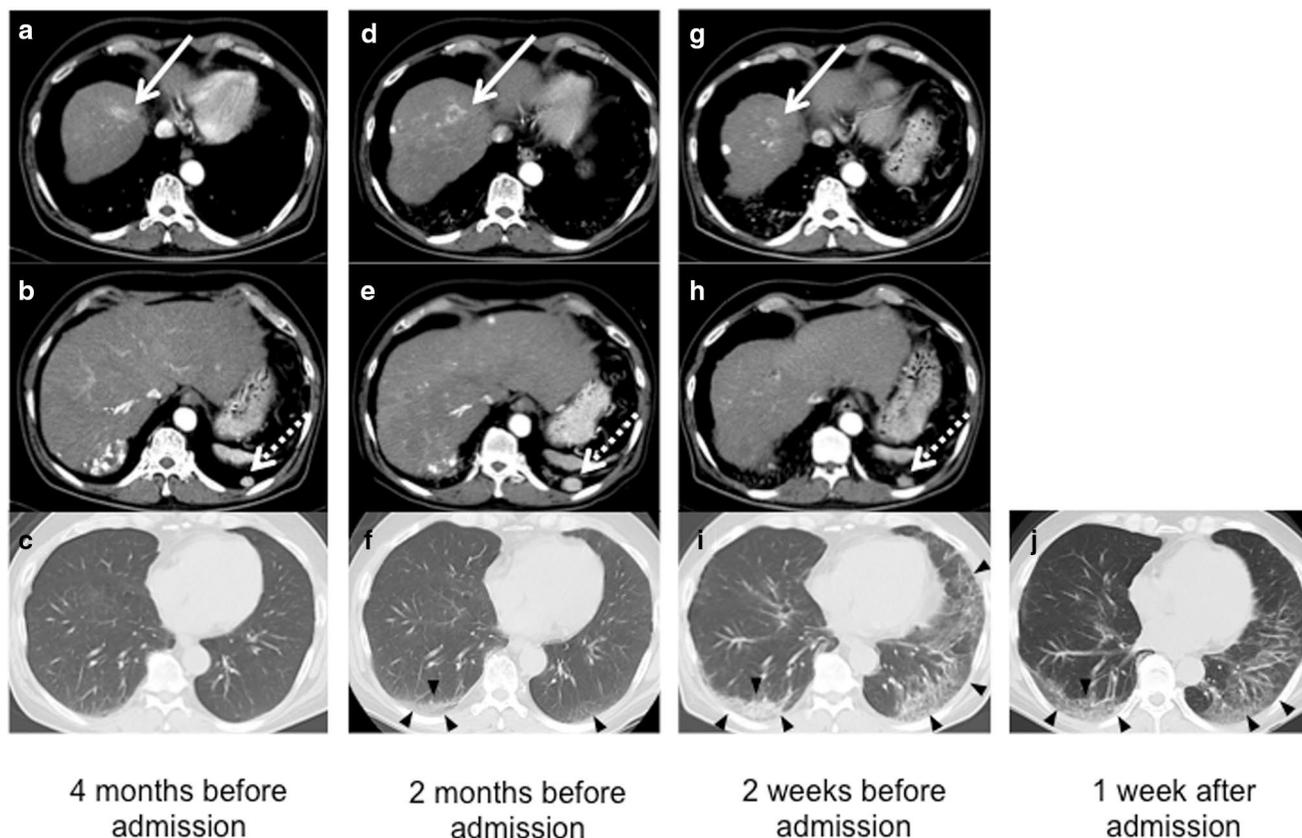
Computed tomography (CT) image before introduction of regorafenib, 4 months before admission (a–c). a Intrahepatic hepatocellular carcinoma (HCC) (arrow) and b lung metastasis in the left lower lung field (broken line arrow) are observed. c There is no shadow suspicious of pneumonia in the lung field. CT image taken 2 months after starting regorafenib treatment (d–f). d Intrahepatic HCC (arrow) and e lung metastasis (broken line arrow) tend to increase. At that time, f reticular shadows appear in both lower
